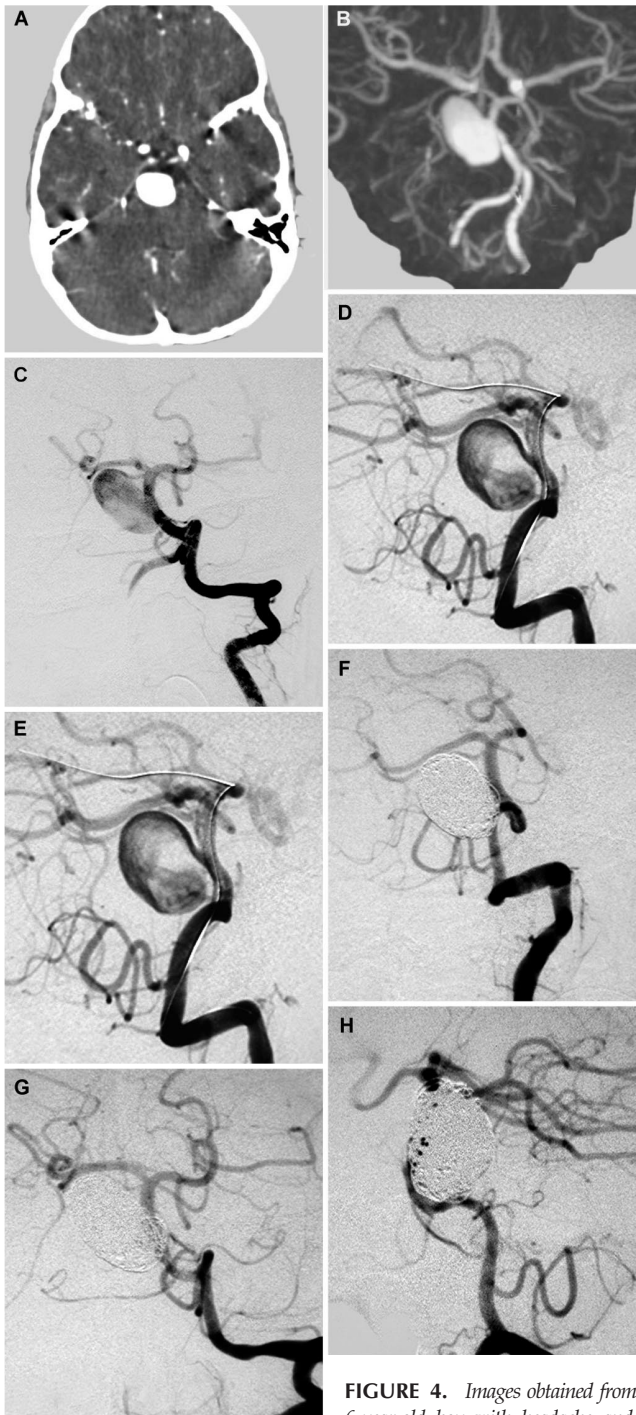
Images obtained from a 6-year-old boy with headache and a large right compressive paraspinal extraaxial mass. A, brain CT scan with contrast demonstrating an enhancing compressive mass. B, CT angiography demonstrating a giant right anterior inferior communicating artery aneurysm. C and D, anteroposterior and lateral views of left vertebral artery angiograms. E, working projection of left vertebral angiogram demonstrating coronary balloon-mounted stent deployed in position spanning the neck. F, final working projection view of angiogram demonstrating left vertebral injection and complete coil occlusion. G and H, final anteroposterior and lateral projections demonstrating complete coil occlusion.
